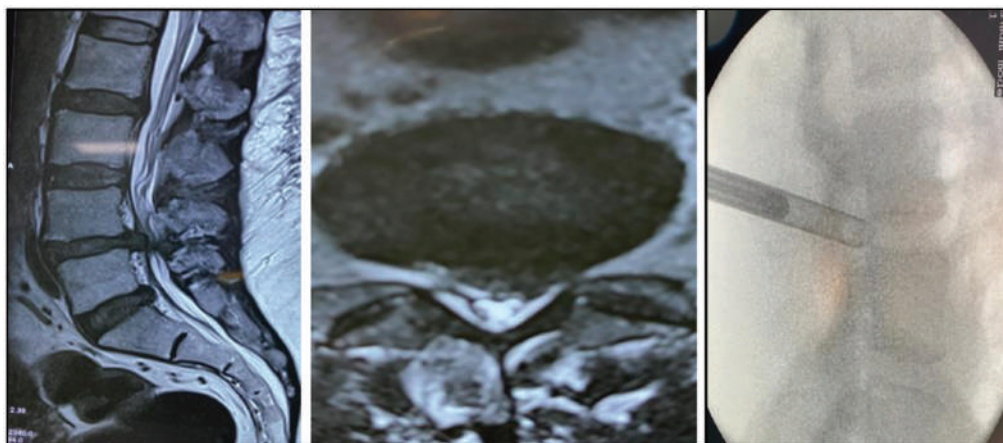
Magnetic resonance imaging showing a foraminal disc and endoscope positioned under fluoroscopy supervision
